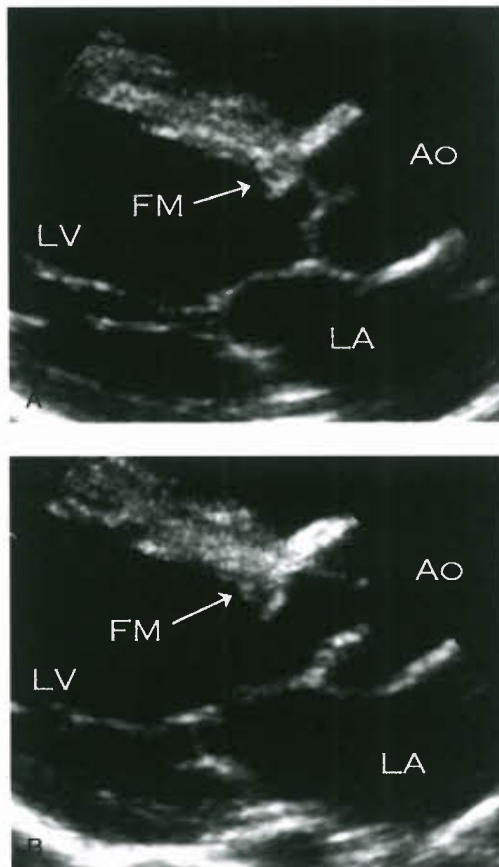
Echocardiographic parasternal long-axis views of fibromuscular subaortic stenosis, with broad-based subaortic fibromuscular ridge. A: Diastole, with aortic valve closed. B: Systole, with aortic valve open.
